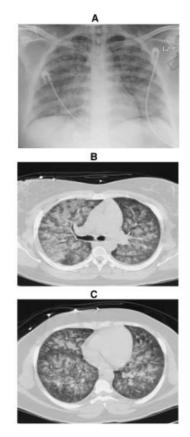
(A) Plain radiograph showing opacity in bilateral lungs with perihilar predominance; (B and C) Axial CT scan shows alveolar confluent and ground glass opacity in the lungs with septal thickening.¹⁸
